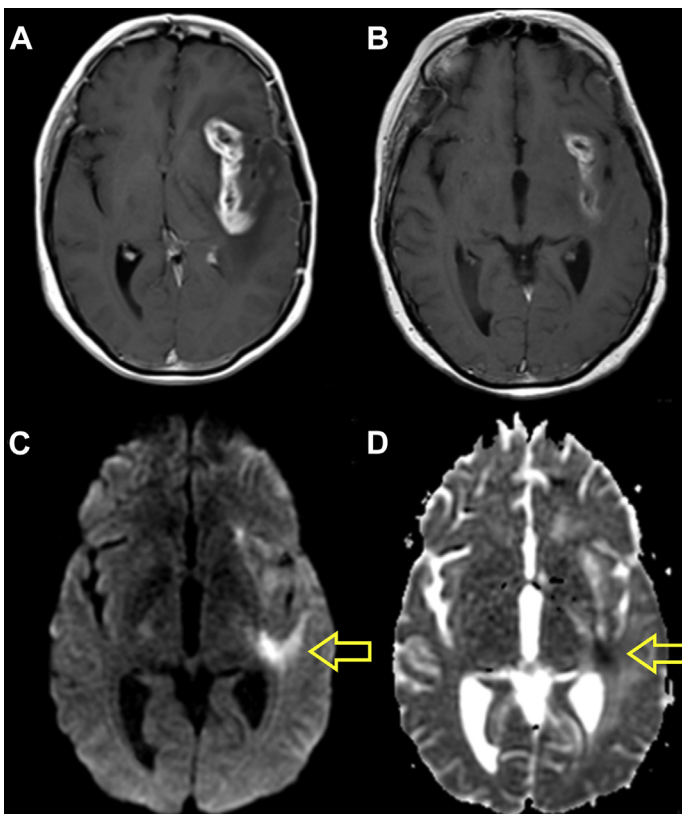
Glioblastoma treated with bevacizumab demonstrating reduction of enhancement on pretreatment (A) and follow-up (B) T1 postcontrast images. Follow-up DWI (C) and ADC (D) shows diffusion restriction in the left temporal stem in the region of previous enhancement (arrows), corresponding to ischemic necrosis. Attention to this area on follow-up diffusion imaging is needed to assess for continued tumor response.
